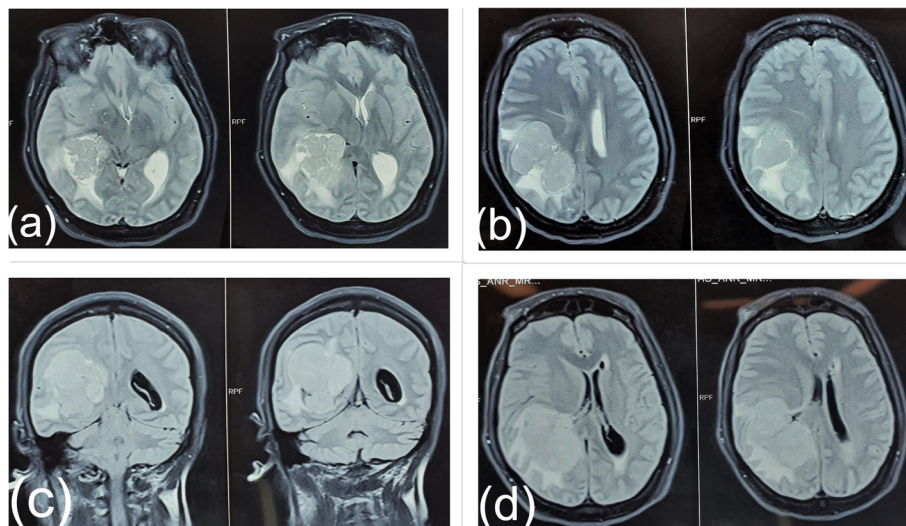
a, b MRI scan brain T2WI axial image shows large trigonal meningioma. c, d Brain MRI FLAIR image shows trigonal meningioma with mass effect
